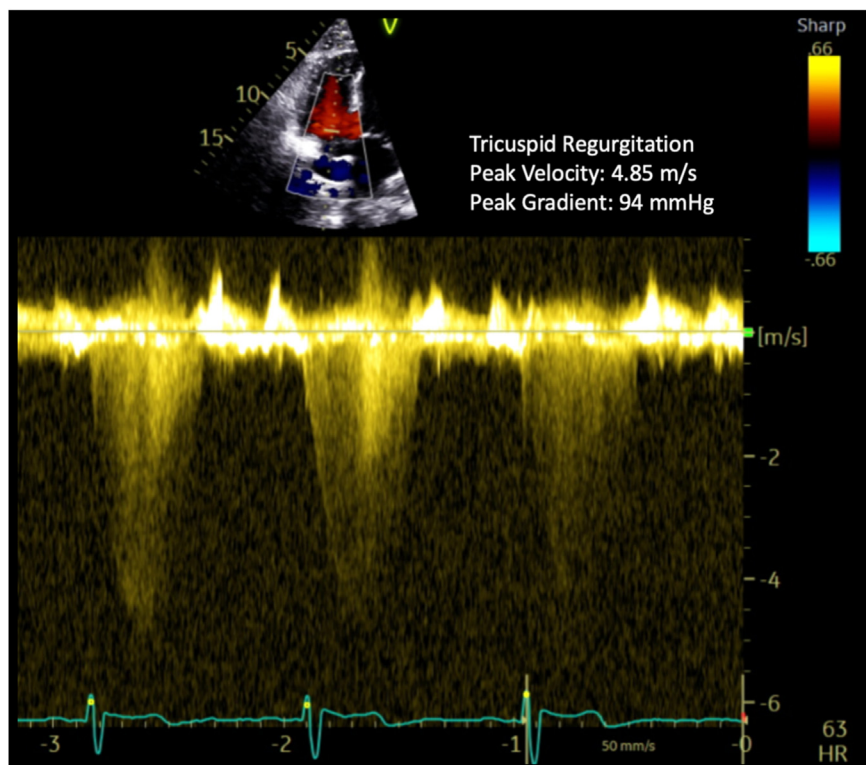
Two-dimensional TTE continuous-wave spectral Doppler tracing, apical 4-chamber view, demonstrates trace TR, which estimates an elevated RVSP (94 mm Hg above the RA pressure).
